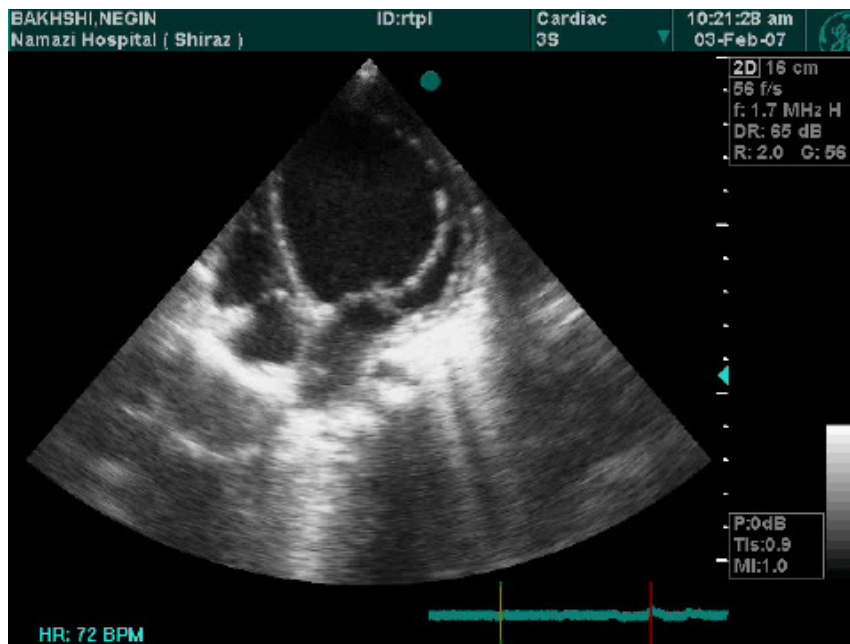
Two-dimensional echocardiography (4 chamber view) of patient No. 3, reveals severely dilated left ventricle, as sign of dilated cardiomyopathy in our patient with ALCAPA.
